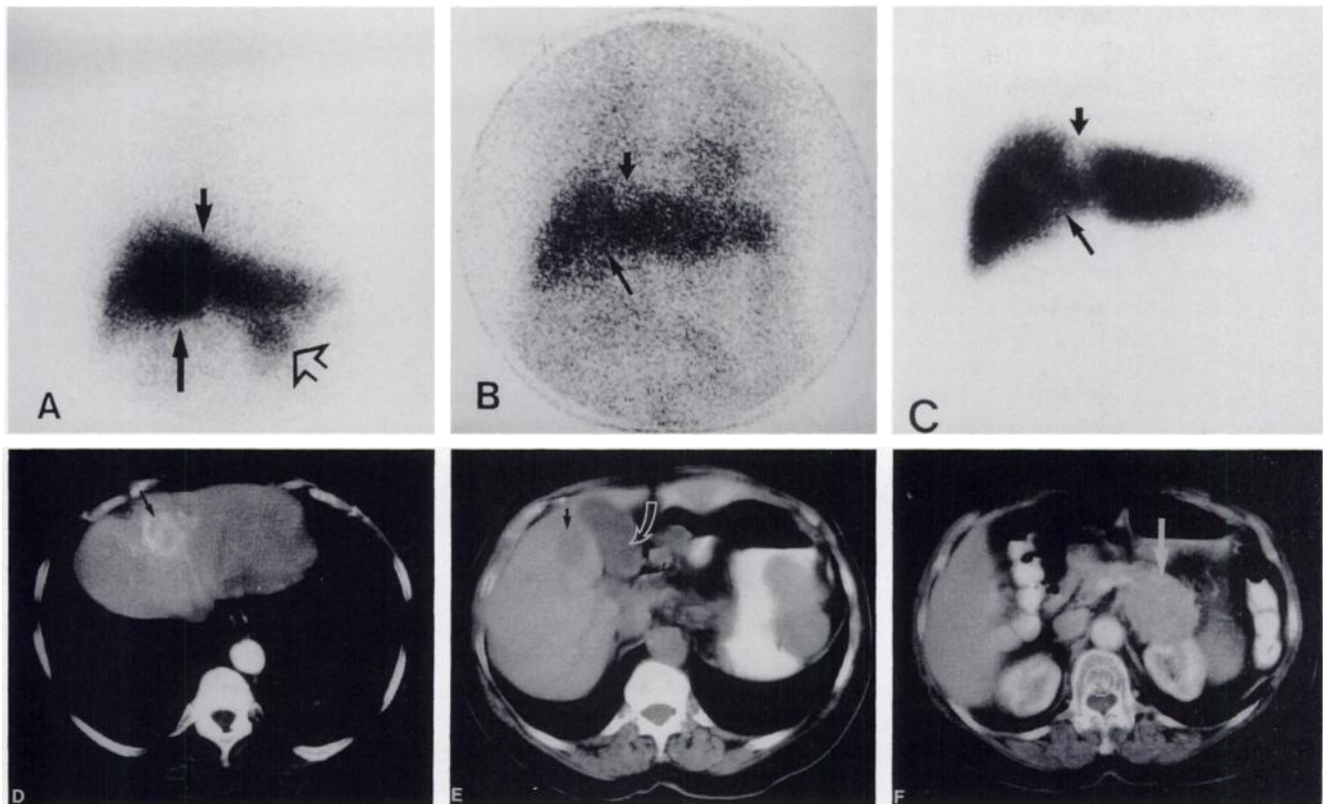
Patient 7, anterior view. (A) Iodine-123-TOCT scan (dose 185 MBq) at 20 min shows two metastatic sites in the liver (arrows). It is difficult to separate the activity in the lesion near the gallbladder (large arrow) from the adjacent biliary activity. Open arrow shows recurrence in the pancreatic tail. (B) Iodine-123-MIBG scan (dose 180 MBq) 48 hr postinjection. No uptake is seen in one of the liver metastases (small arrow), while the other shows Grade 2 uptake (large arrow). The site of tumor recurrence in the pancreatic tail is not visualized. (C) Technetium-99m-colloid liver scan shows two photon-deficient areas in the liver (arrows). (D) CT scan performed on the same patient at the same time shows a hepatic lesion (arrow) near the superior surface of the liver. (E) Closed arrow indicates a second metastatic site adjacent to the gallbladder and open arrow indicates gallbladder. (F) Arrow indicates recurrence in the pancreatic tail.
